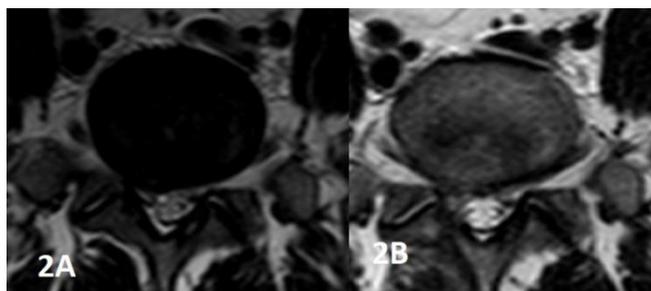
Axial T2-weighted magnetic resonance image through the L5-S1 disc showing the right mediolateral disc herniation (2A). Postoperative lumbar MRI one month later after surgery (2B)
